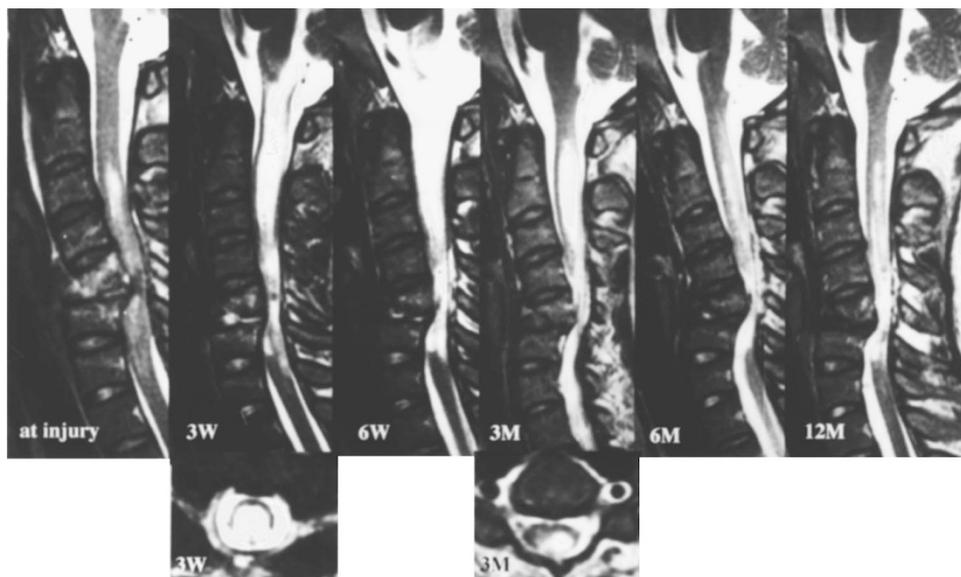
A 19-year-old woman. Paralysis was grade A. MRI showed the signal changes which suggested the pencil-shaped softening of the cervical cord
